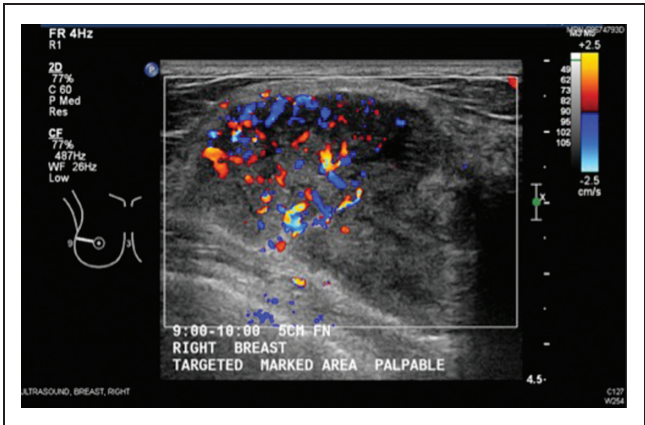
Ultrasound scan of the right breast revealing a heterogeneous vascular mass with fairly well-circumscribed margins in the right breast
